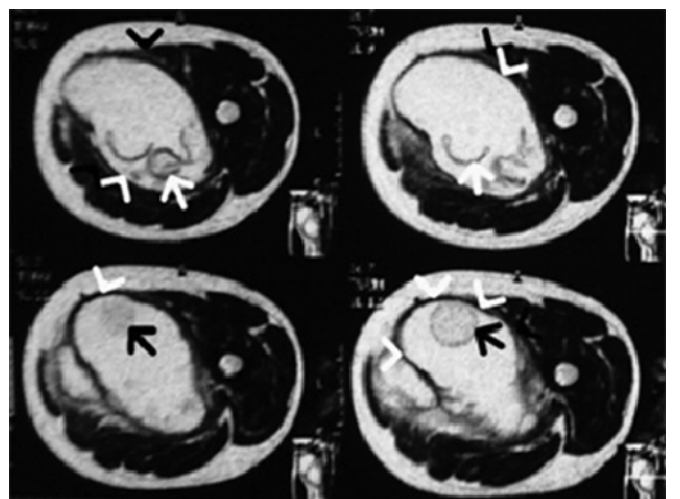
MRI of the left thigh demonstrating "Water-Lily" sign. Axial T2-weighted images demonstrate collapsed membrane in the dependent portion of the mother cyst (white arrows) producing the "Water-Lily" sign, incomplete double layer of the mother cyst is also noted (white and black arrow heads). The daughter cyst has lower signal intensity than the mother cyst in T2-weighted images.
